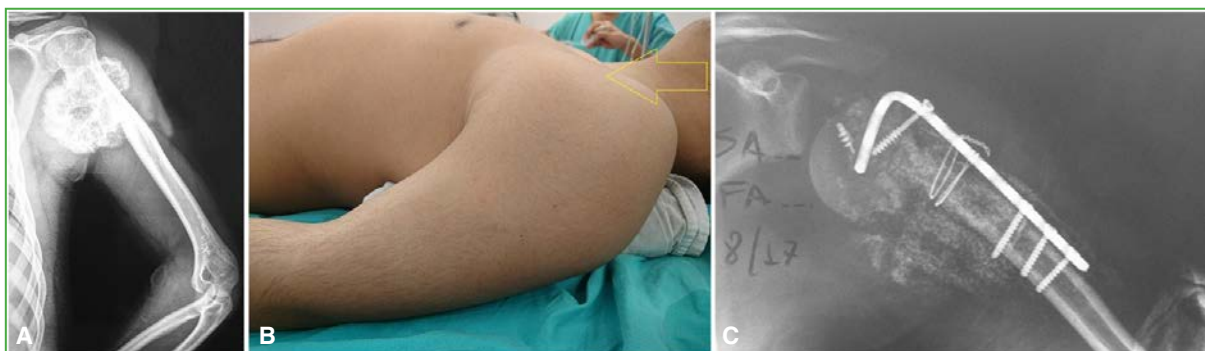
Case 3. Proximal humeral osteochondroma. A. Preoperative anteroposterior radiograph of a left proximal humeral osteochondroma (179.6 cm^3). B. Preoperative clinical appearance. C. Radiograph at 18 months postoperatively showing pseudarthrosis.
